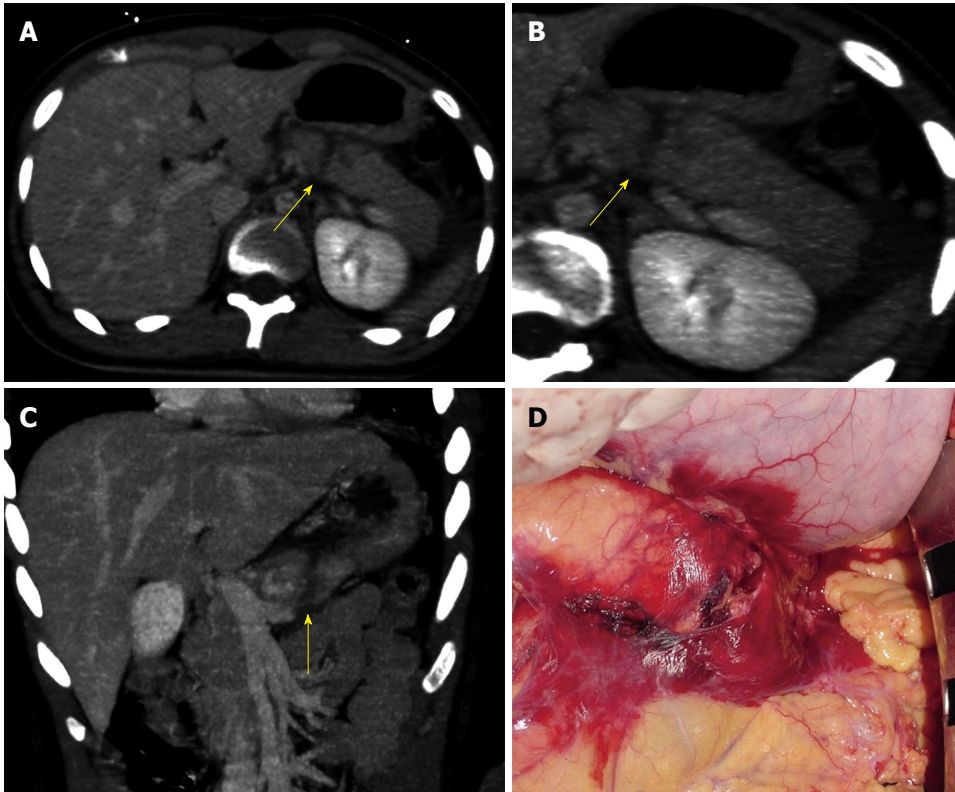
Computed tomography and intra-operative findings of pancreatic parenchymal fracture. A: CT image on axial plan showing a complete laceration of the pancreatic body appearing as a low-attenuation line oriented perpendicular to the long axis of the pancreas (arrow); B: CT image on axial plan showing a complete laceration of the pancreatic body appearing as a low-attenuation line oriented perpendicular to the long axis of the pancreas (arrow); C: CT image on coronal plan showing a complete laceration of the pancreatic body appearing as a low-attenuation line oriented perpendicular to the long axis of the pancreas (arrow); D: Intra-operative finding confirming the CT diagnosis of post-traumatic laceration of the pancreas. CT: Computed tomography.
